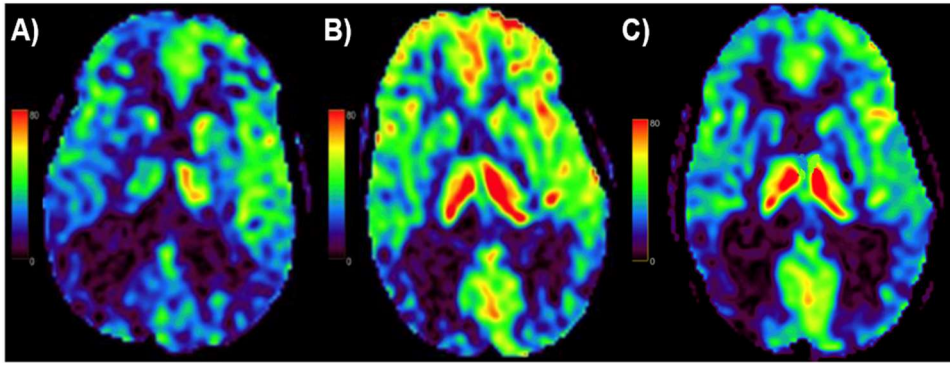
Patient 2 cerebral blood flow color map: A) CBF map showing hypoperfusion in the frontal, parietal, and occipital lobes, more pronounced on the right. B) CBF map after the fourth dose of lecanemab, demonstrating marked improvement in cerebral perfusion, especially in the bilateral frontal lobes. C) CBF map after the sixth dose of lecanemab, showing decreased overall perfusion compared to the post-fourth dose MRI, but still an improvement from baseline.
